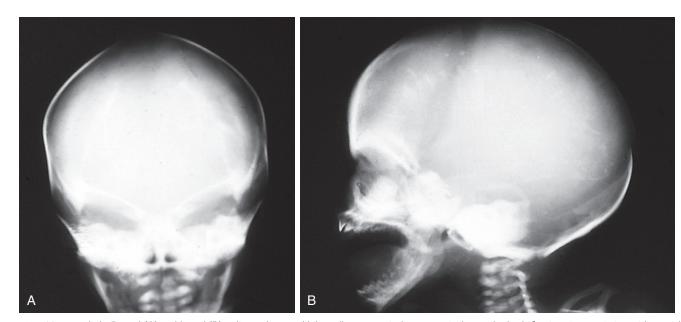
Macrocephaly. Frontal (A) and lateral (B) radiographs reveal bilaterally symmetrical, paraventricular cerebral calcifications in association with cranial enlargement in an infant with congenital cytomegalovirus infection. (Courtesy Department of Radiology, Children's Hospital of Pittsburgh, Pittsburgh, Pa.)
